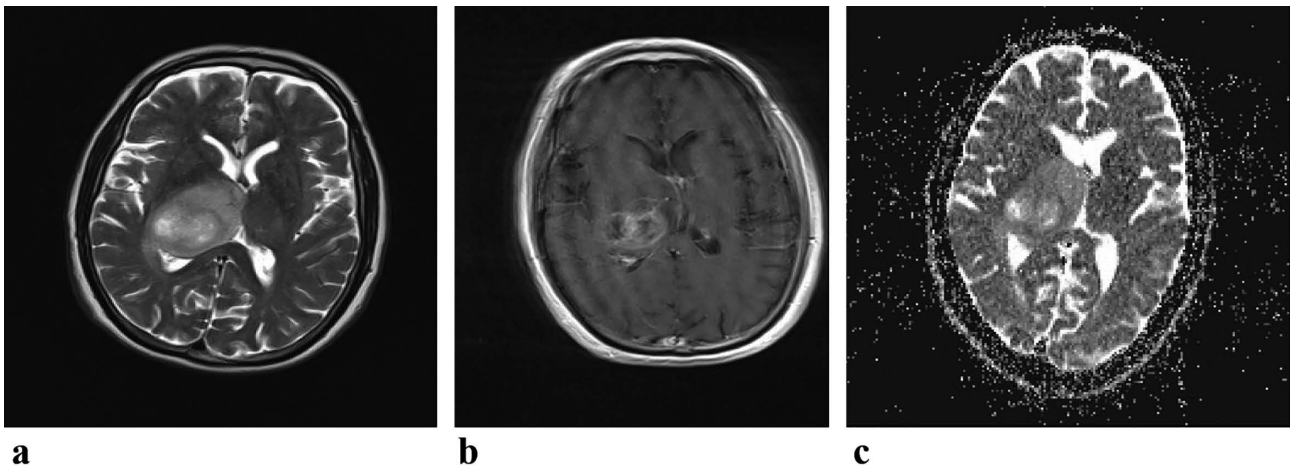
GBM in 43-year-old man. Transverse (a) preoperative T2-weighted MR image (3600/96), (b) contrast-enhanced T1-weighted MR image (440/14), and (c) ADC map show welldefined tumor (arrows in a) in right thalamus region. Irregular enhancing area is noted in center of tumor (in b). Minimum ADC value was $0.891 \times 10^{-3} \text{ mm}^2 \cdot \text{sec}^{-1}$.
